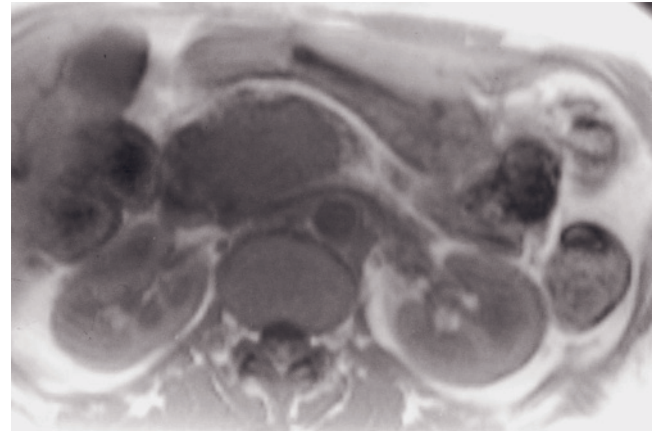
(Continued) fat-suppressed spin-echo (*d*) images. A large 5-cm cancer is present in the head of the pancreas that is low in signal intensity on T1-weighted images (*b*) and low in signal intensity on T2-weighted images (*a*) and enhances minimally on early (*c*) and late (*d*) postgadolinium images. This represents the typical appearance of a large pancreatic ductal cancer. Liver metastases are present and are most clearly defined on immediate postgadolinium images as focal low-signal intensity masses with irregular rim enhancement (arrows, *c*). The liver is the most common site for metastatic lesions from primary pancreatic cancer.
